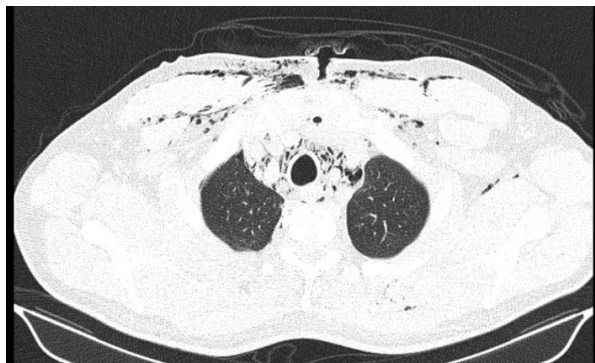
Breast CT data – the spread of gas, inflammatory infiltration into the anterior-inferior mediastinum, posterior-superior mediastinum, intercostal spaces
